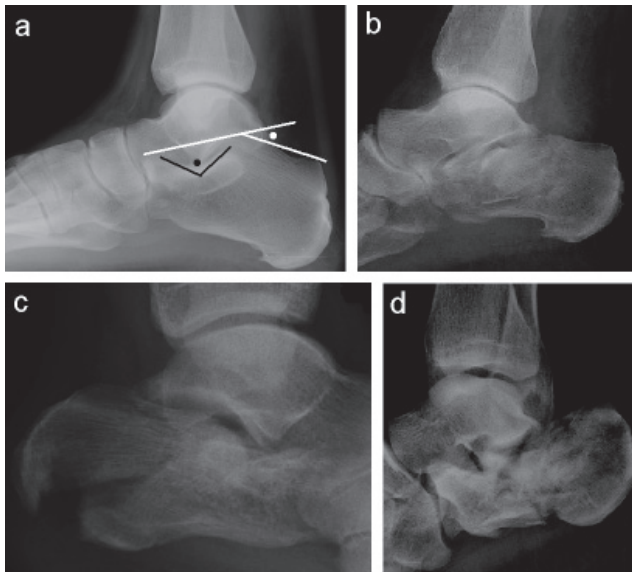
Conventional radiographs
